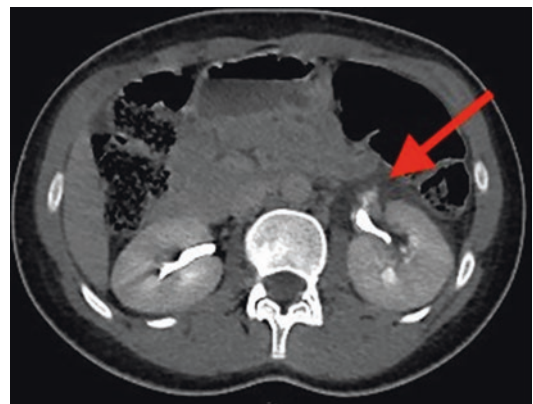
This contrast-enhanced delayed-phase axial CT of the abdomen shows a blush of contrast around the left renal pelvis (red arrow) indicating rupture of the left renal collecting system
